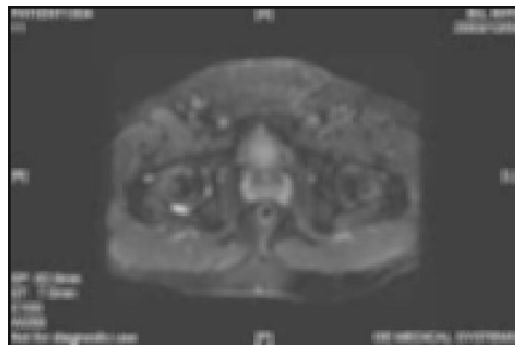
T2-weighted magnetic resonance imaging scan showing areas of high signal in the femoral heads bilaterally, along with peripheral serpiginous low signal (figure 1 and figure 2 show the same patient).
